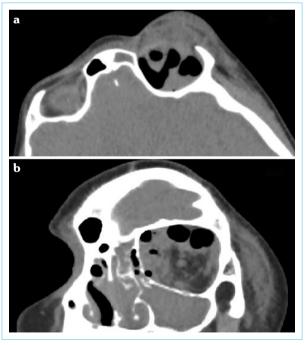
(a, b) Computed tomography sections show air density in the left orbit
